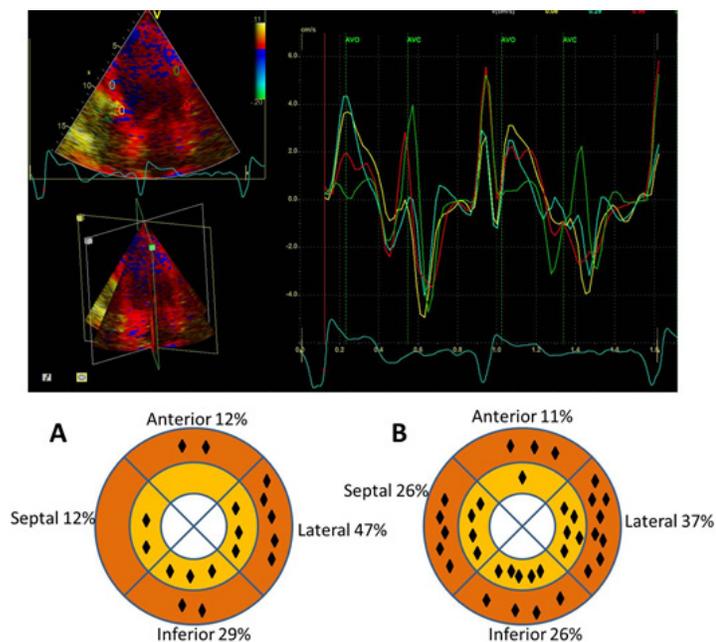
Assessment of left ventricular (LV) dyssynchrony with triplane tissue Doppler imaging (TDI) in 17 patients with dilated cardiomyopathy and QRS duration >120 ms (A) and in 35 patients with ischemic cardiomyopathy and QRS duration >120 ms (B). The upper panel shows the assessment of LV dyssynchrony from the apical 4-chamber view placing 4 regions of interest in the basal and mid ventricular segments. The peak systolic velocity is measured for each mid and basal LV segment within the systolic interval demarcated in the time-velocity graph by the opening (AVO) and closing (AVC) of the aortic valve. The lower panel shows the distribution of the latest activated areas as assessed with triplane TDI in patients with dilated cardiomyopathy (A) and patients with ischemic cardiomyopathy (B). The basal lateral segment is more frequently the most delayed segment in patients with dilated cardiomyopathy whereas in ischemic heart failure patients the distribution is more variable
